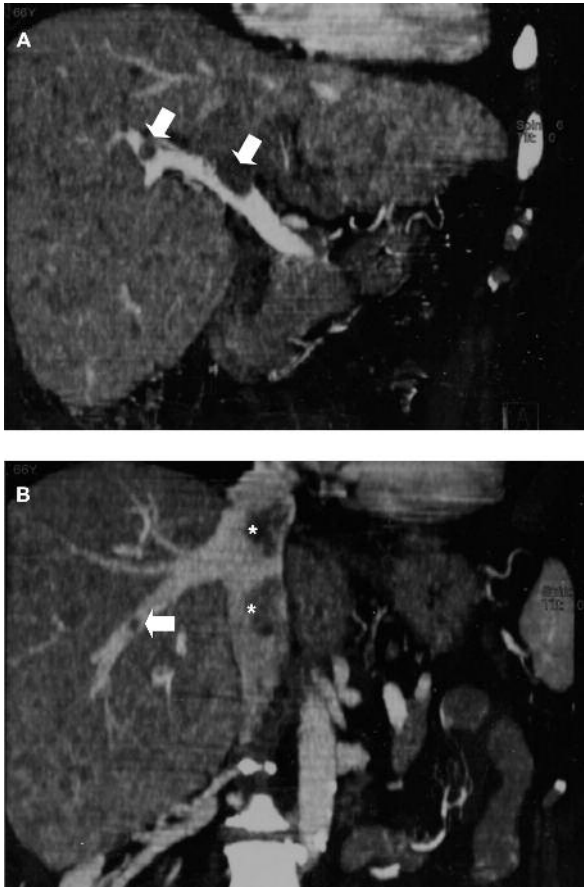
Contrast enhanced abdominal CT scan images (coronal reconstruction). A) Various localizations of portal vein thrombosis (arrows). B) Thrombosis of the middle suprahepatic vein (arrow), and inferior caval vein (asterisks).
